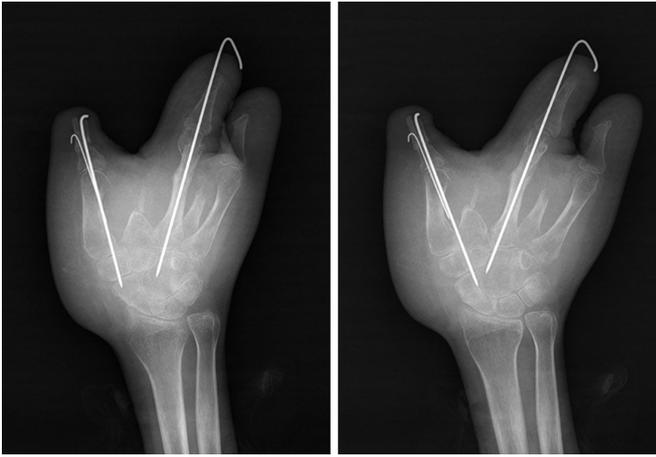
X-ray imaging after treatment.
